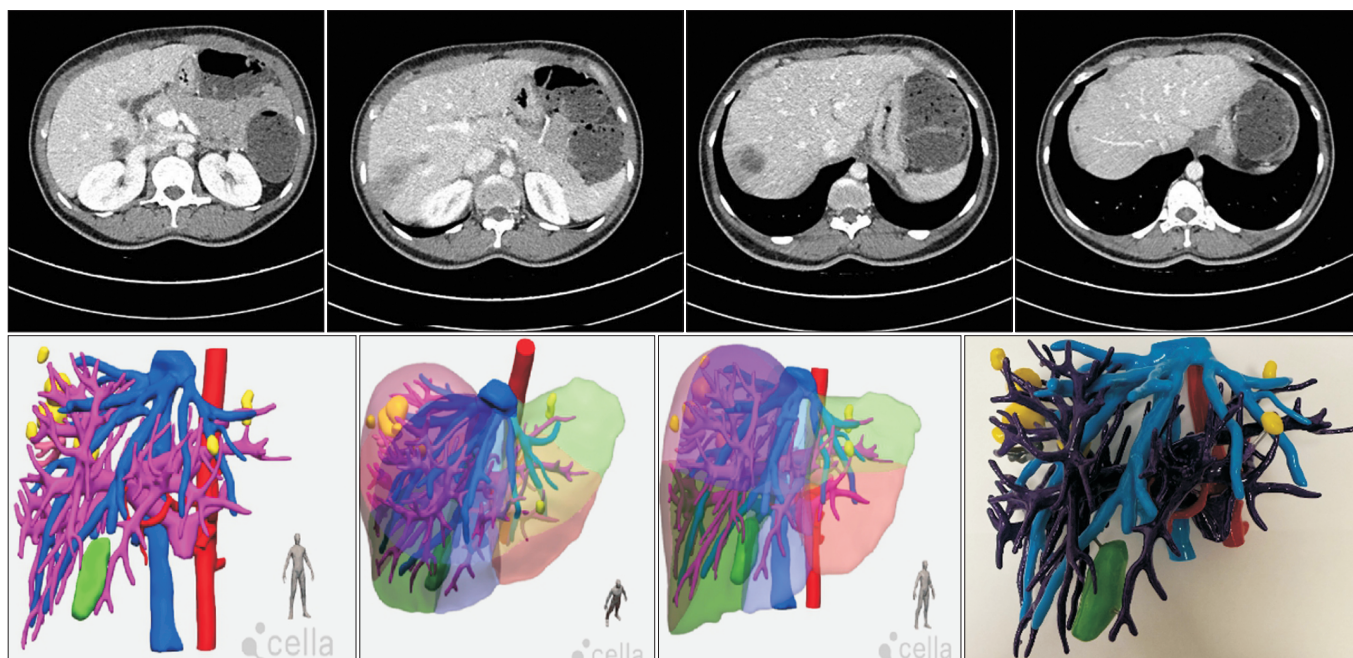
Two-dimensional (2D) computed tomography imaging with overlaid virtual and printed 3D models for a patient with bilobar colorectal liver metastases.
